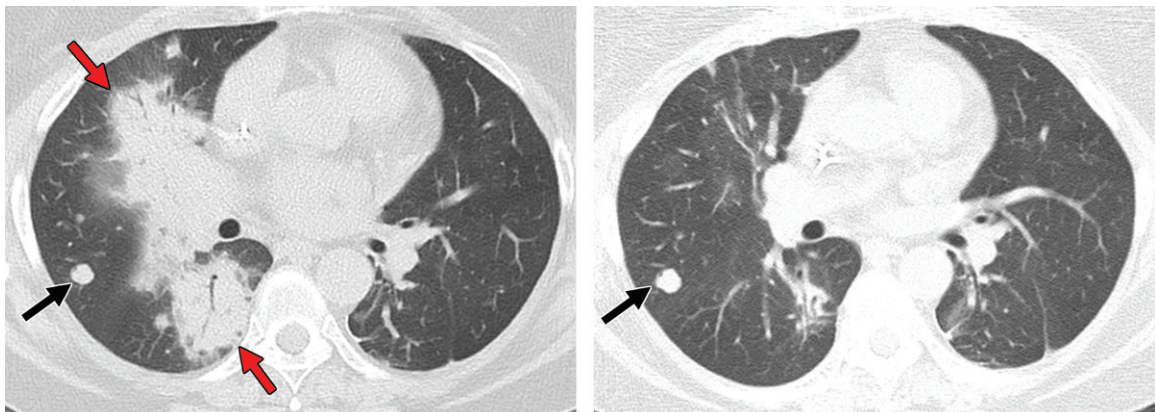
Pneumonitis associated with nivolumab therapy in a 61-year-old woman with metastatic clear cell RCC. The patient presented in the emergency department with shortness of breath 1 month after the initiation of nivolumab therapy. (a) Axial CT image of the chest shows patchy peribronchovascular consolidation, which is most pronounced in the right lower and middle lobes (red arrows). The nivolumab therapy subsequently was stopped, and the patient was given corticosteroids. Black arrow = right middle lobe metastasis. (b) Axial CT image of the chest obtained 1 month later shows near-complete resolution of consolidation. Arrow = right middle lobe metastasis.
